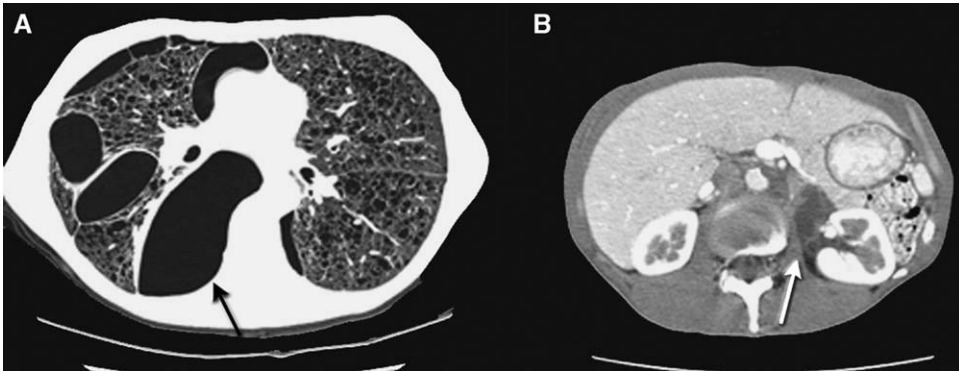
LAM. HRCT image shows multiple cysts with interspersed normal lung (A) and right pneumothorax (black arrow). CT of the abdomen (B) shows low-attenuation retroperitoneal masses caused by lymphangiomas (white arrow).
